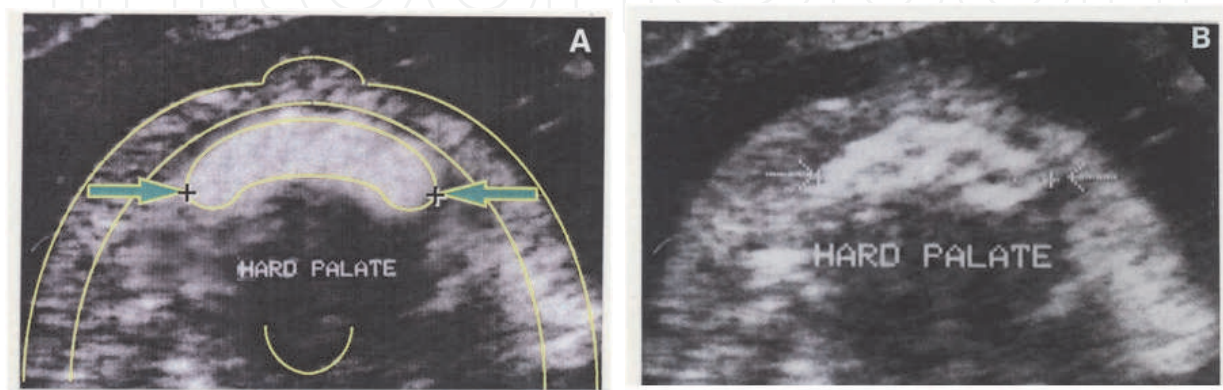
Sonographic picture of normal primary palate (The alveolar ridge)
